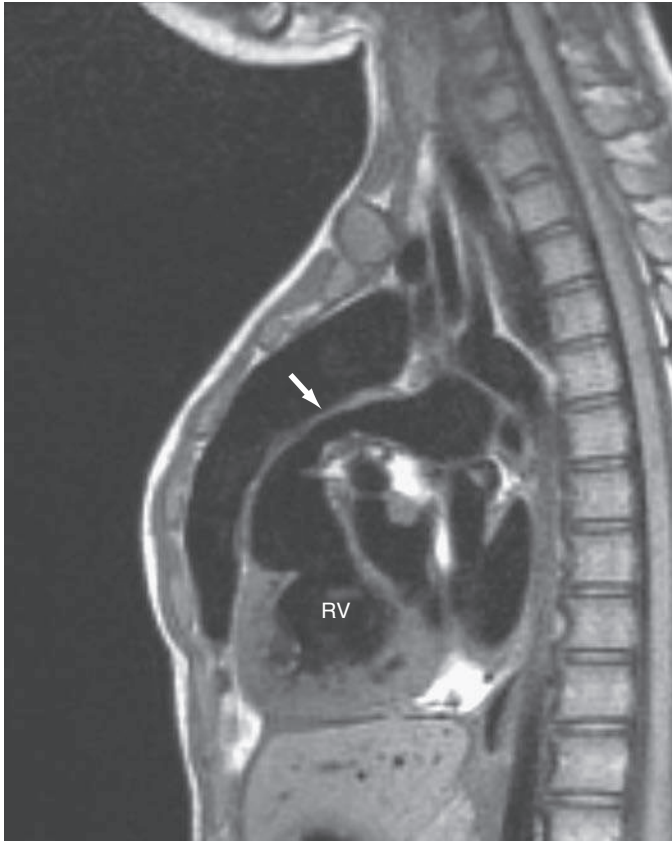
Magnetic resonance imaging scan of a patient after the Rastelli operation. The arrow indicates severe stenosis of the pulmonary conduit.
